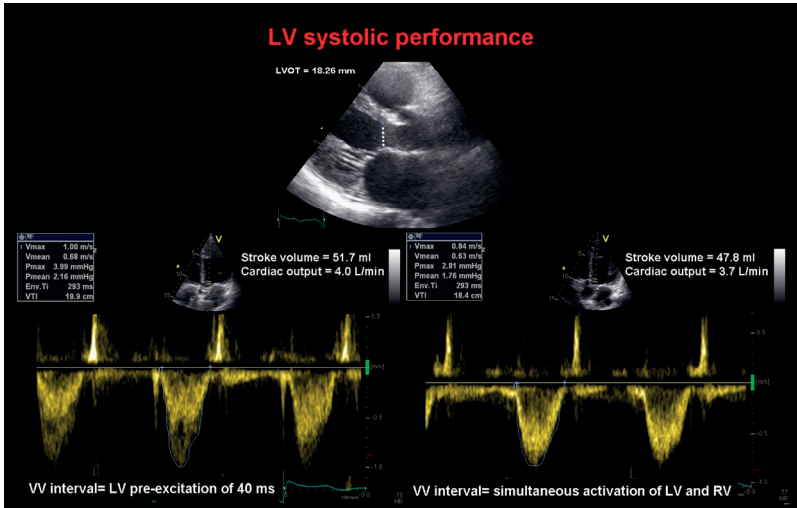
Example of VV interval optimization by measuring stroke volume and cardiac output. Velocity-time integral (VTI) at left ventricular outflow tract (LVOT) is measured with pulsed-wave Doppler echocardiography. Stroke volume can be derived by multiplying the cross sectional area (CSA) with VTI. Cardiac output can be derived by multiplying stroke volume with heart rate (HR). $CSA = \pi/4 \times LVOT$ diameter; $Stroke\ volume = CSA \times VTI$; $Cardiac\ output = stroke\ volume \times HR$.
